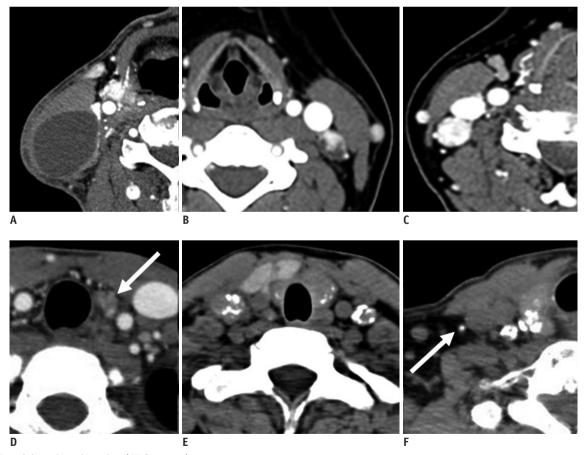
Suspicious lymph nodes (CT features).
